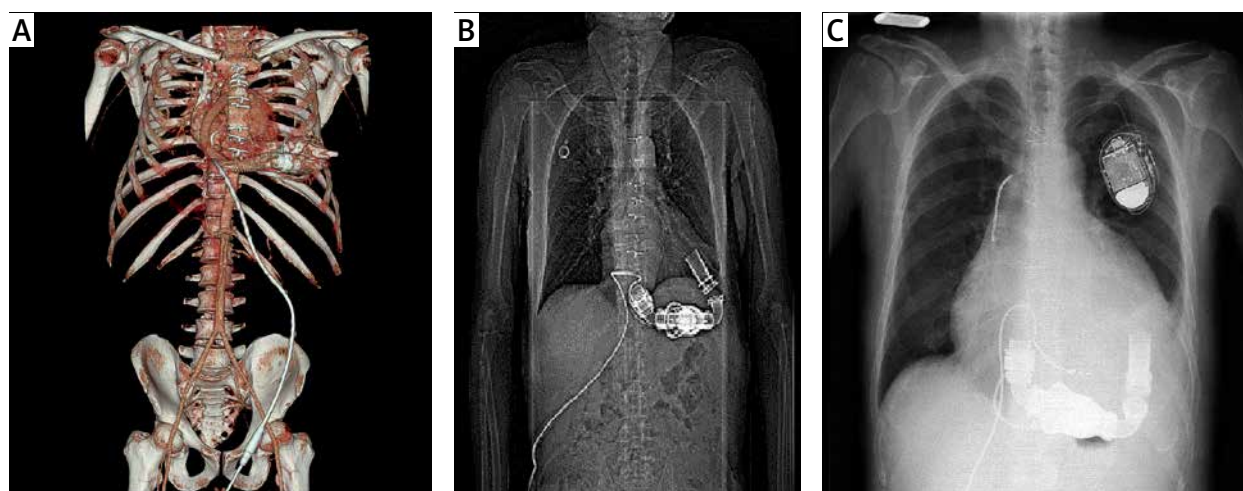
Computed tomography and posterior anterior chest X-ray scout film shows the location of the LVAD and LVAD driveline in the chest and abdomen
